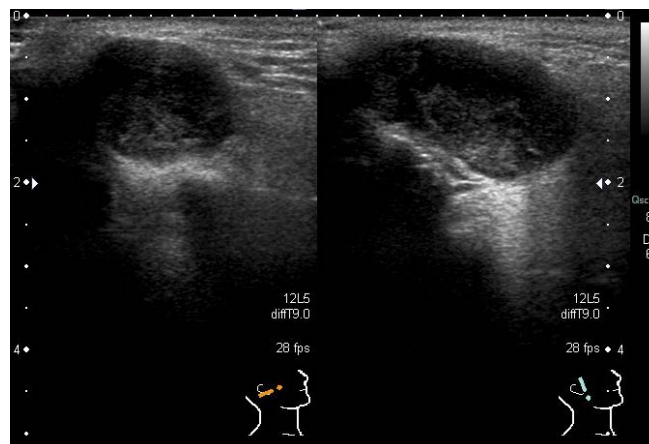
Ultrasonography revealed a uniform cystic lesion measuring approximately 2.5 cm in diameter within the right parotid gland.
